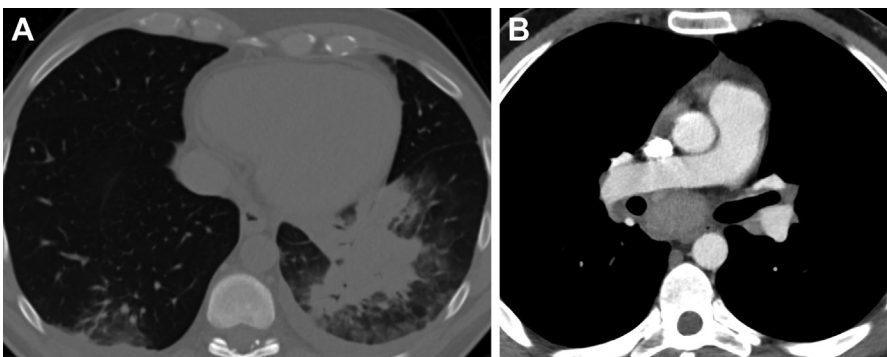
Two CT images of the chest from a patient residing in Arizona demonstrate (A) dense left lower lobe consolidation with surrounding ground glass and septal thickening, as well as (B) presence of multifocal mediastinal lymphadenopathy on soft tissue images. Coccidioidomycosis was diagnosed via positive serologies.
